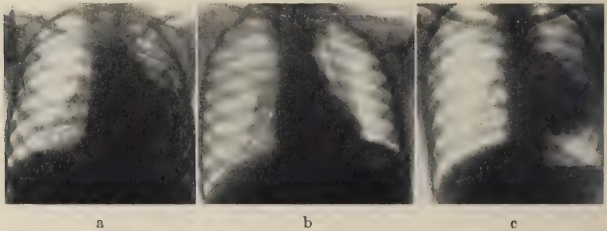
Roentgenogram of the lungs on admission, showing marked involvement of the left lung with displacement of the mediastinal structures to the left side. The appearance is most suggestive of the terminal stage of a destructive type of suppurative pneumonia associated with bronchiectasis.
